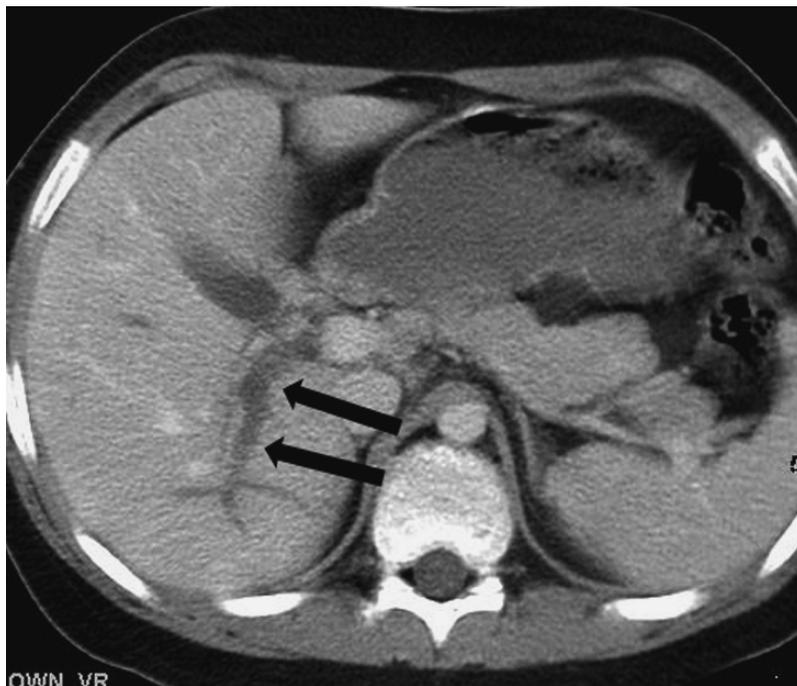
PTE. This CT scan in a patient with diffuse abdominal pain after appendectomy shows a nonenhancing right portal vein (arrows) consistent with thrombosis.
